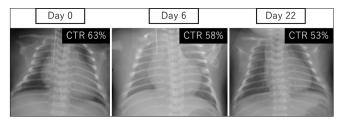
Chest radiograph of the neonate. Cardiomegaly was gradually ameliorated
